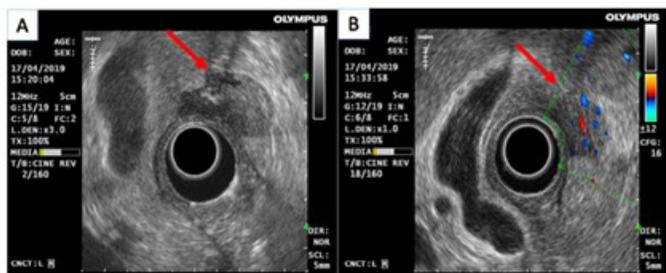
and 3B: Endoscopic ultrasound showed a 2 cm hypochoic lesion appeared to be arising from muscularis propria layer of duodenal wall with increased doppler signal and internal calcification.
